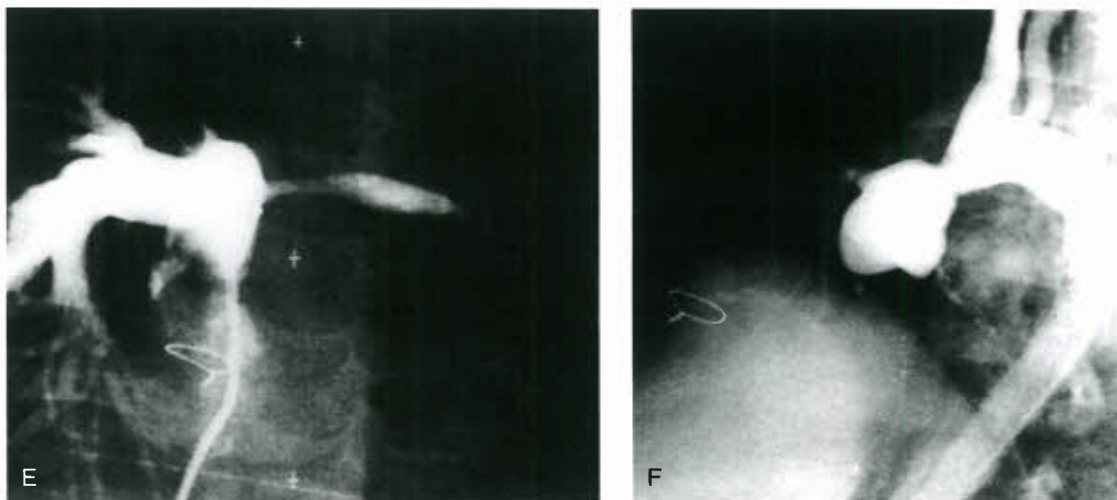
(Continued) (E) angiogram in the main pulmonary artery showing severe stenosis and hypoplasia of the left pulmonary artery. This patient had TGA/IVS with side-by-side great arteries; following the LeCompte maneuver, the left pulmonary artery draped over the aortic anastomosis causing, in addition, moderate supravalvular aortic stenosis (F) (with a peak systolic ejection gradient from left ventricle to aorta of 30 mm Hg). A lung perfusion scan demonstrated that 95% of the pulmonary blood flow entered the right lung. Following balloon angioplasty, the diameter of the left pulmonary artery increased by 200%, and the left lung flow increased to 22% by follow-up lung scan. (Parts A–D from Wernovsky G, Hougen TJ, Walsh EP, et al. Midterm results after the arterial switch operation for transposition of the great arteries with intact ventricular septum: clinical, hemodynamic, echocardiographic and electrophysiologic data. *Circulation* 1988;77:1333–1344, with permission.)
